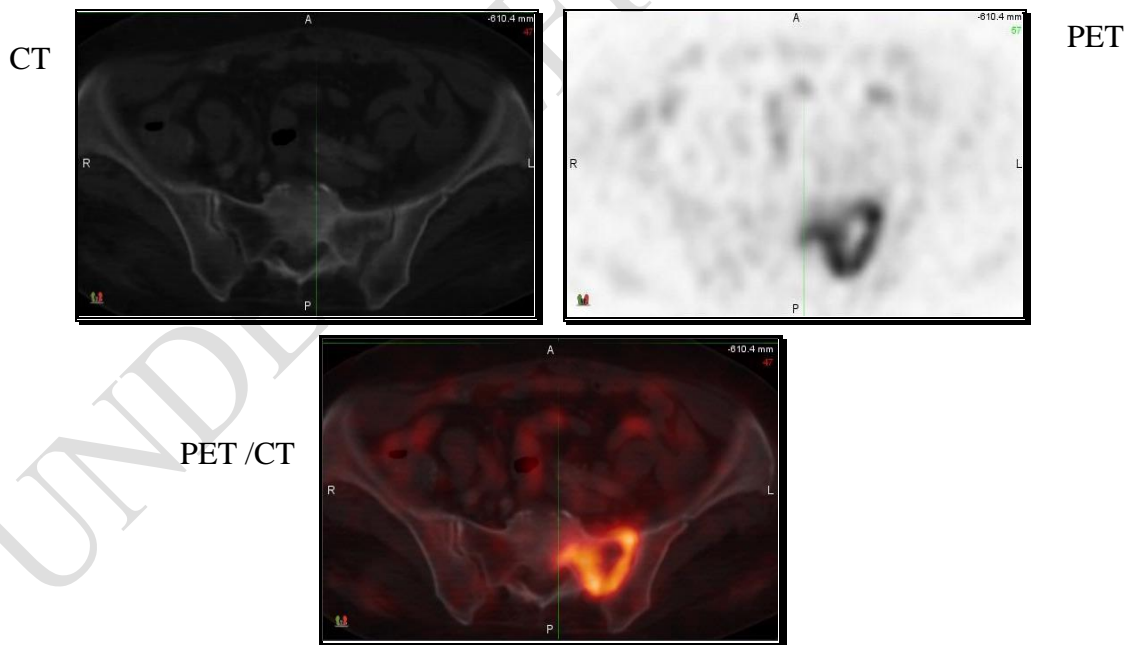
Axial CT, PET and PET/CT image shows the left ala of the sacrum metastatic deposit.
